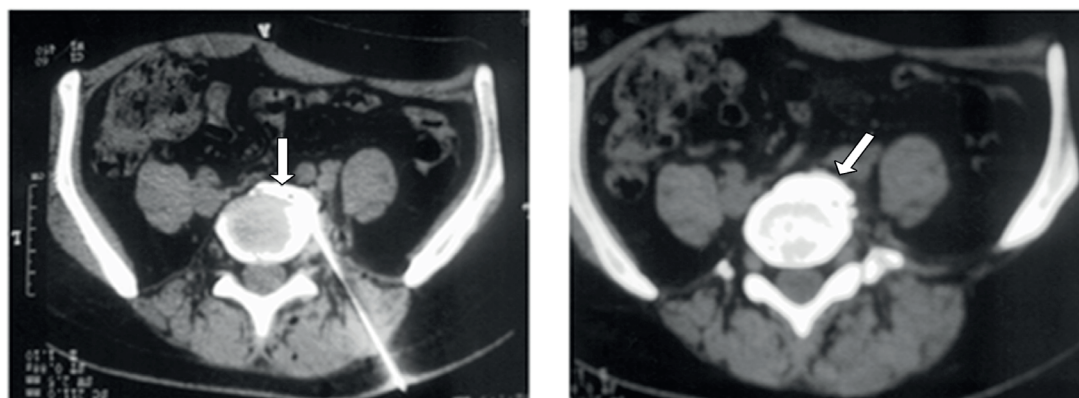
Computed tomography images. Contrast medium spread during the superior hypogastric plexus block through the L5-S1 intervertebral disc. CTs show appropriate placement of the needle tip and adequate spread of contrast medium (arrows) around the target plexus.
